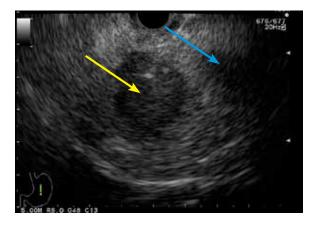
Linear endoscopic ultrasound image of a 30-mm heterogeneous mass in the pancreatic neck (yellow arrow) and a 35-mm hypoechoic mass within the body of the pancreas (blue arrow).
